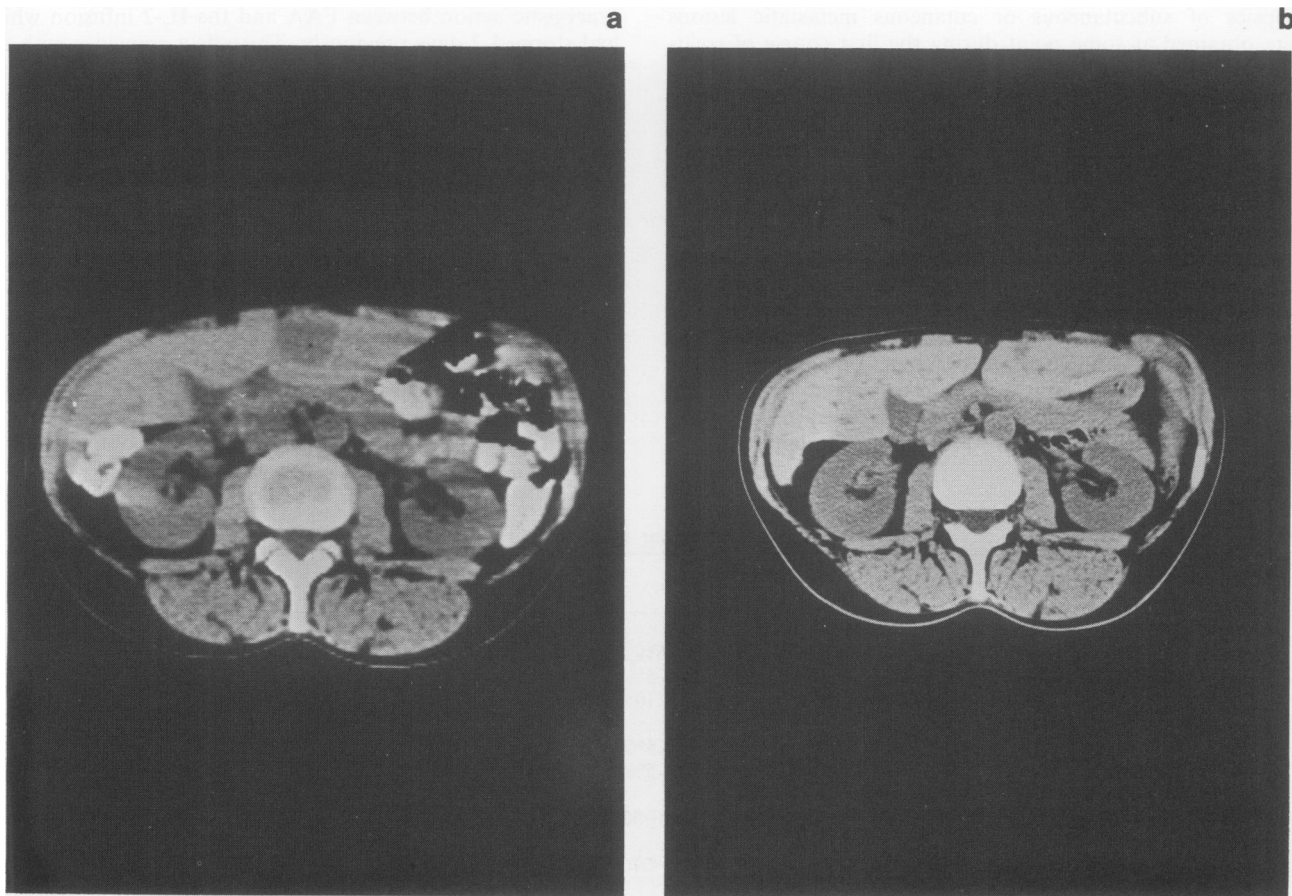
a, Pretreatment scan (October 1990). b, Liver metastasis in partial remission (March 1991). Repeat CT scan and ultrasound of liver in October 1991 showed no evidence of liver metastasis.
